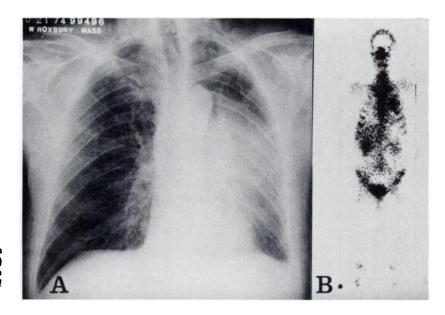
(A) Chest radiograph shows tumor mass in left hilar region; and (B) anterior Tc-polyphosphate bone scan shows accumulation of isotope in area of tumor mass seen on chest x-ray.
